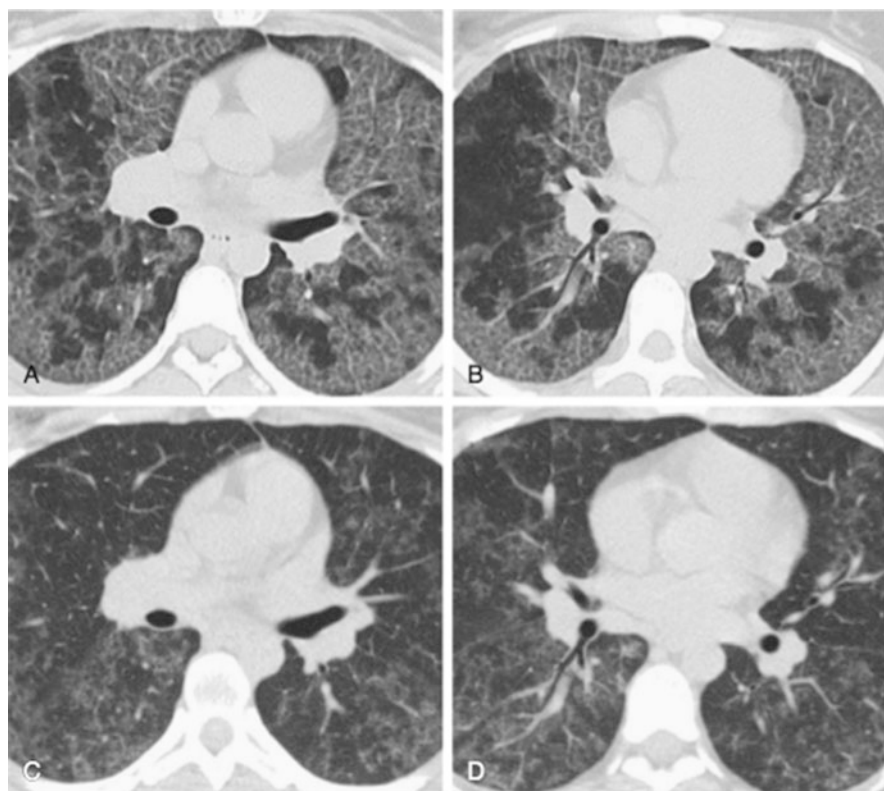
Axial high-resolution CT images obtained at the initial time of diagnosis shows the typical appearance of “crazy paving” (a and b). Axial chest CT images obtained a year later showing reduction in ground-glass opacities. Patient had not undergone any therapy (spontaneous resolution). Reprinted from Murray & Nadel’s Textbook of Respiratory, 6th edition, Authors: Trapnell, BC. And Luisetti, M., Pulmonary Alveolar Proteinosis Syndrome, Page No. 1274e8, Copyright 2016, with permission from Elsevier (Courtesy: Michael Gotway, MD.)
